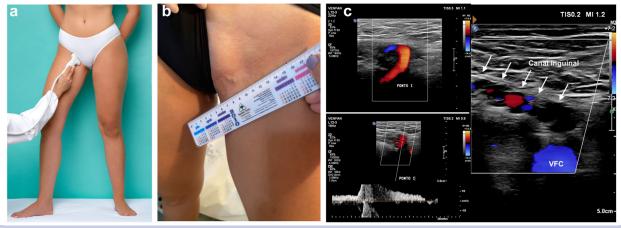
A, Location of the inguinal escape point on transperineal ultrasound examination. B, Varicose veins in the inguinal region. C, Inguinal escape point with reflux on color Doppler. Authors archive.
